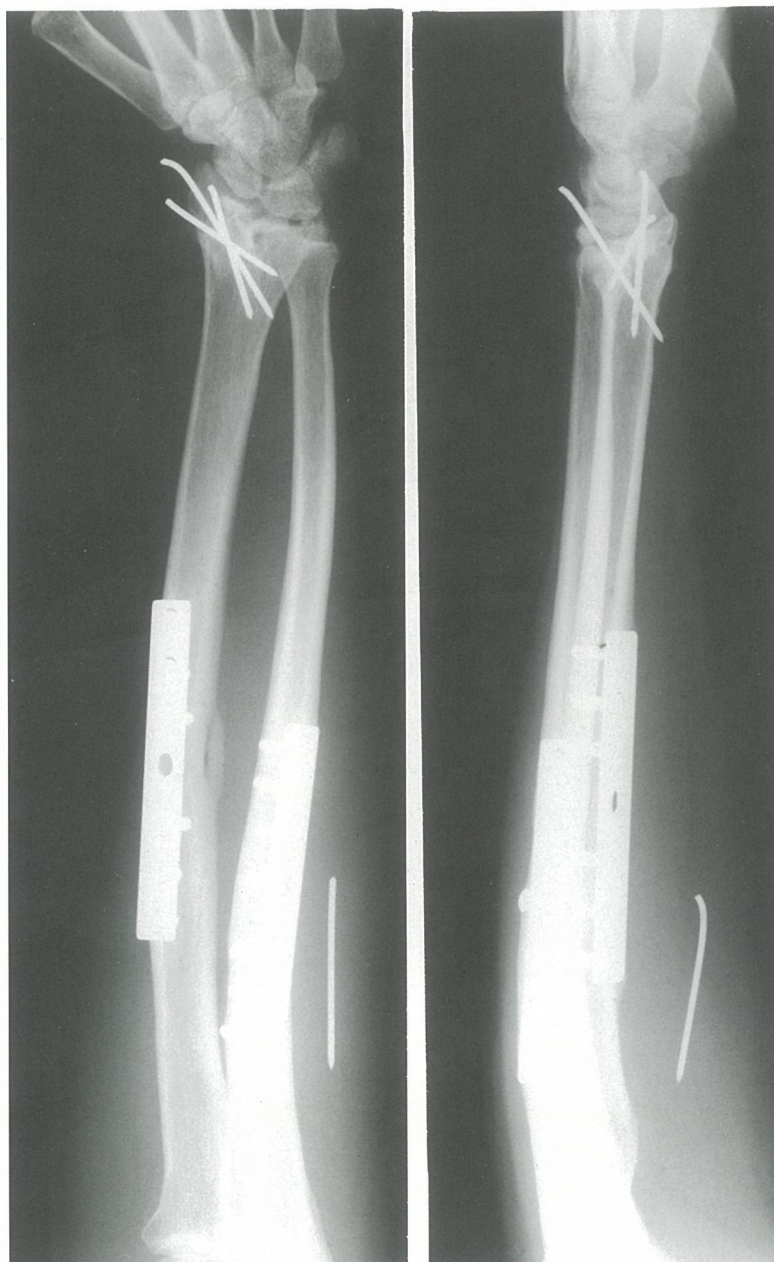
Check radiographs of the same patient seven months after the second accident.
